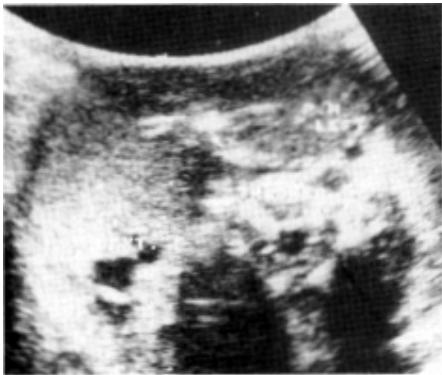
Ultrasonography showed the enlarged, inhomogenous thyroid gland.
